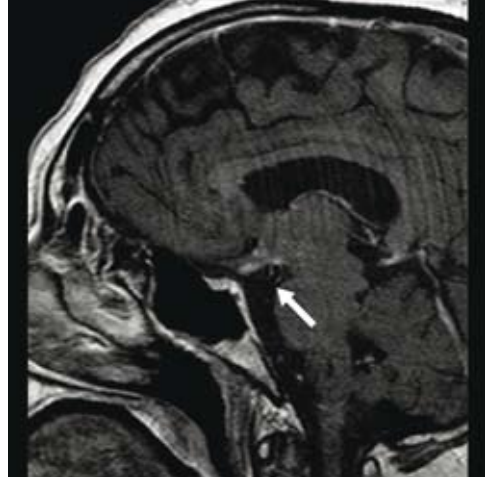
Brain MRI: sagittal flair gadolinium-enhanced.
